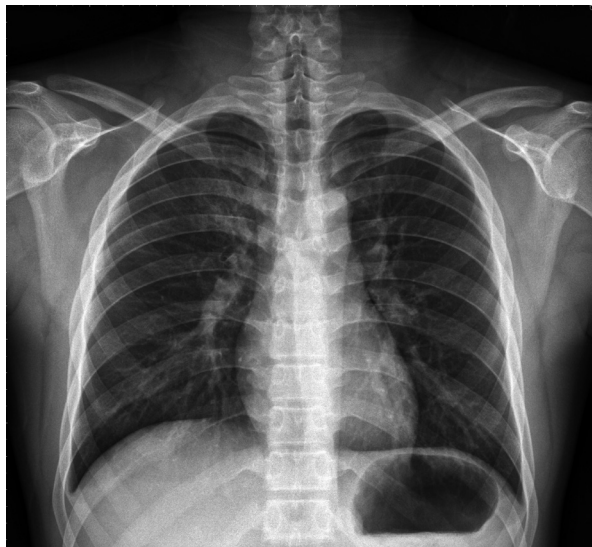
Chest radiography showed improved pulmonary edema with clear lung fields (48 hours post-operation).
